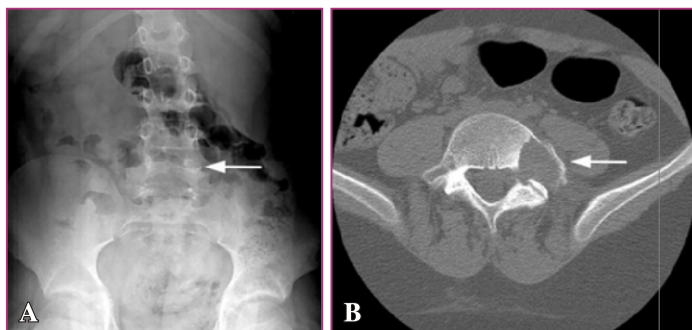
A : AP radiograph of the lumbar spine demonstrating a radiolucent lesion (arrow) involving the right pedicle in an 11 - year - old boy with a 2-month history of low back pain with radicular leg pain and pain at night. A biopsy confirmed osteoblastoma with a secondary aneurysmal bone cyst within the lesion.
